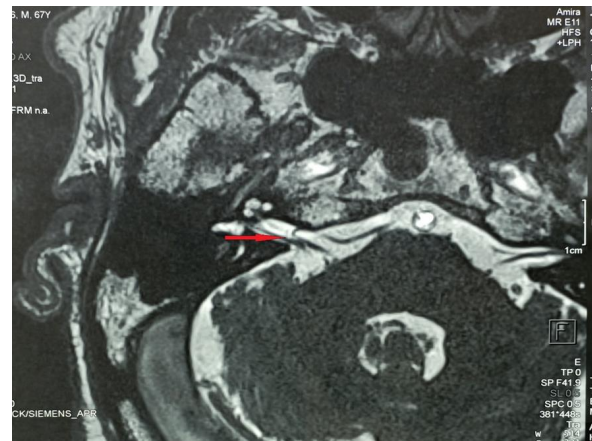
Axial high-resolution T2-weighted MRI showing an AICA vascular loop (red arrow) entering the internal auditory canal at the cerebellopontine angle level. The intimate relationship between the vessel and the vestibulocochlear nerve is clearly demonstrated.
